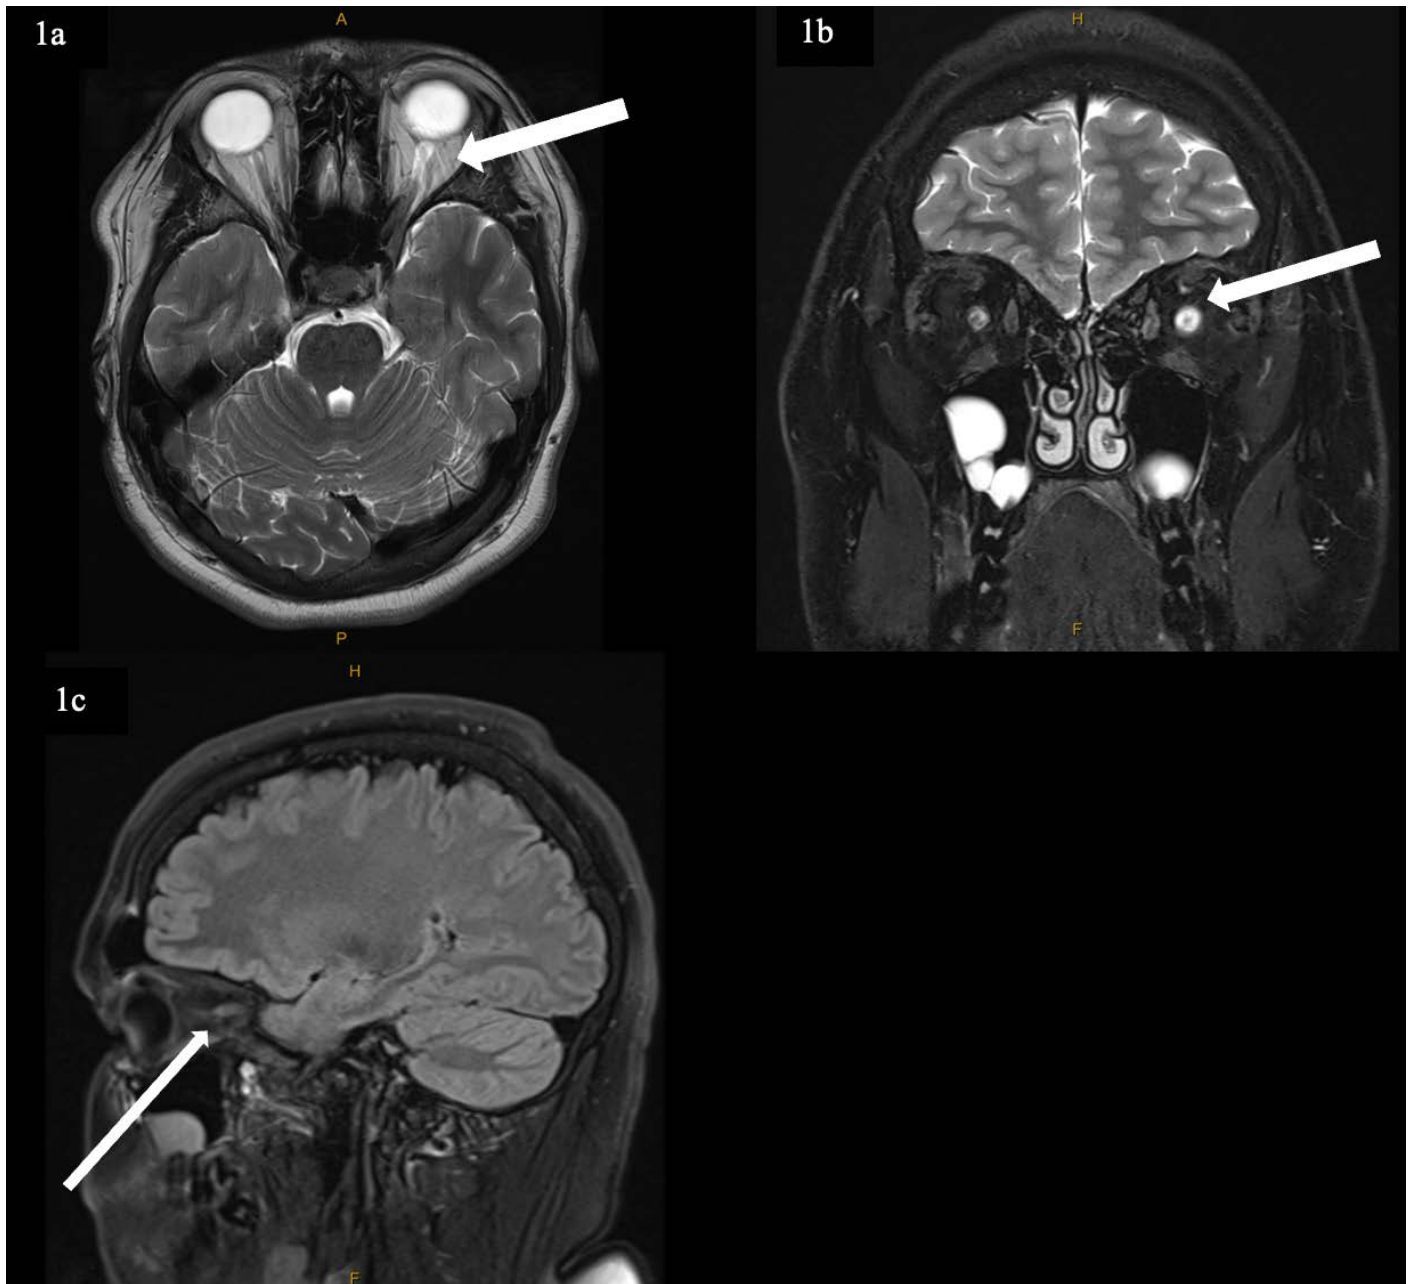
MRI Orbits (a. T2 axial view, b. T2 coronal view, c. Fluid- Attenuated Inversion Recovery (FLAIR) sagittal view)
